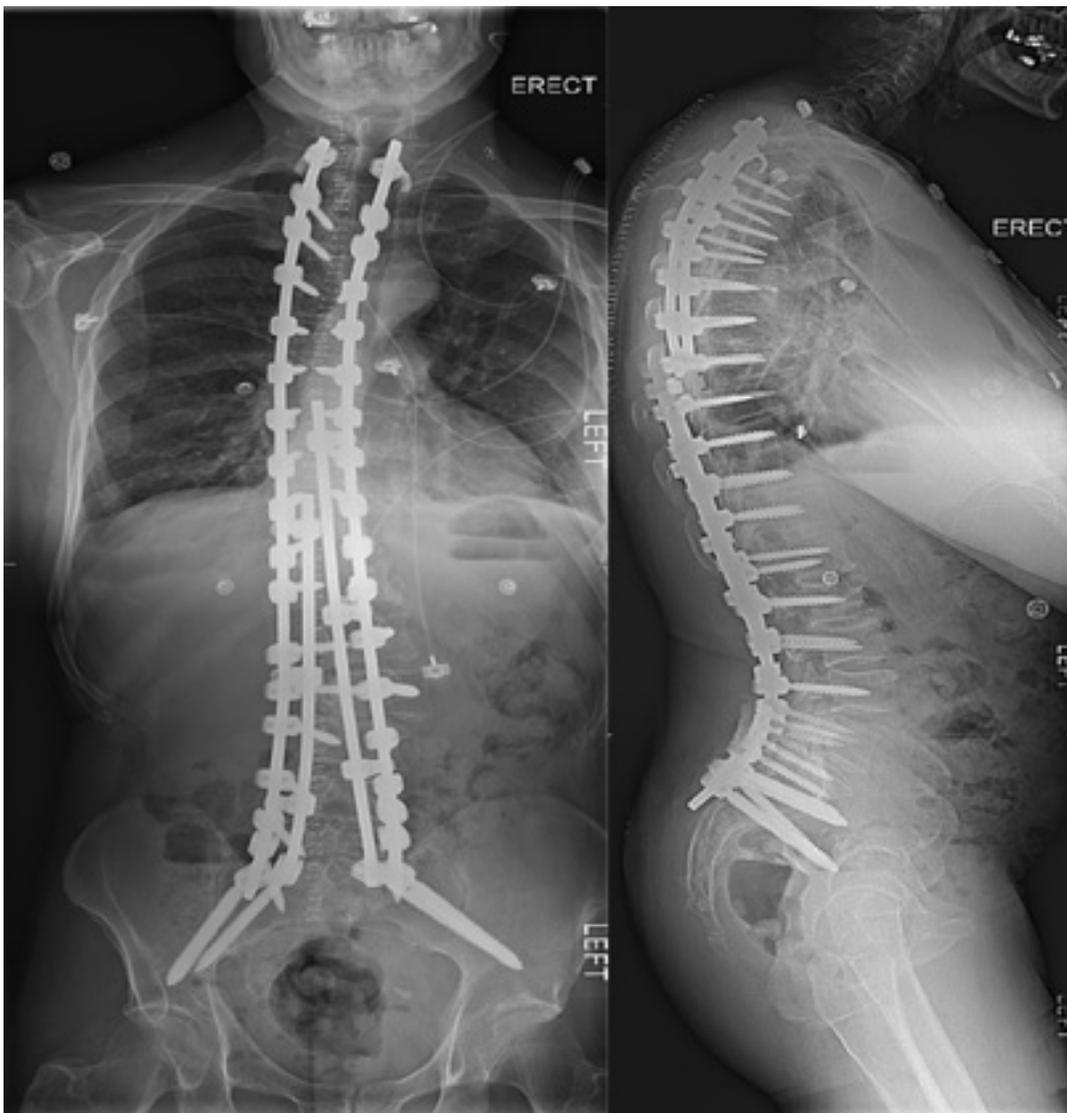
Postoperative radiographs (AP and lateral) demonstrating the "four rods" technique of spinopelvic fusion.
